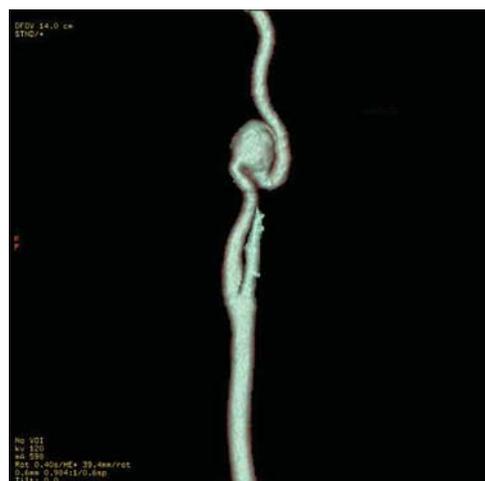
Multislice computed tomography angiography; the right internal carotid artery aneurysm associated with medial kinking
